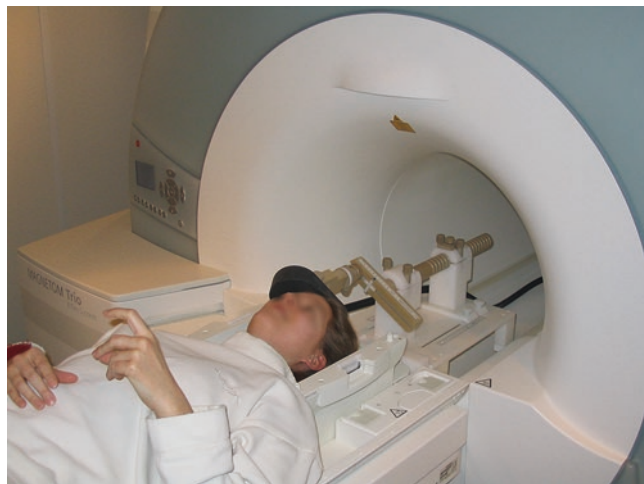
MRI compatible TMS coil and holder apparatus (image courtesy of Dr. A. Thielscher of the Max Plank Institute for Biological Cybernetics <http://www.kyb.mpg.de/>)
